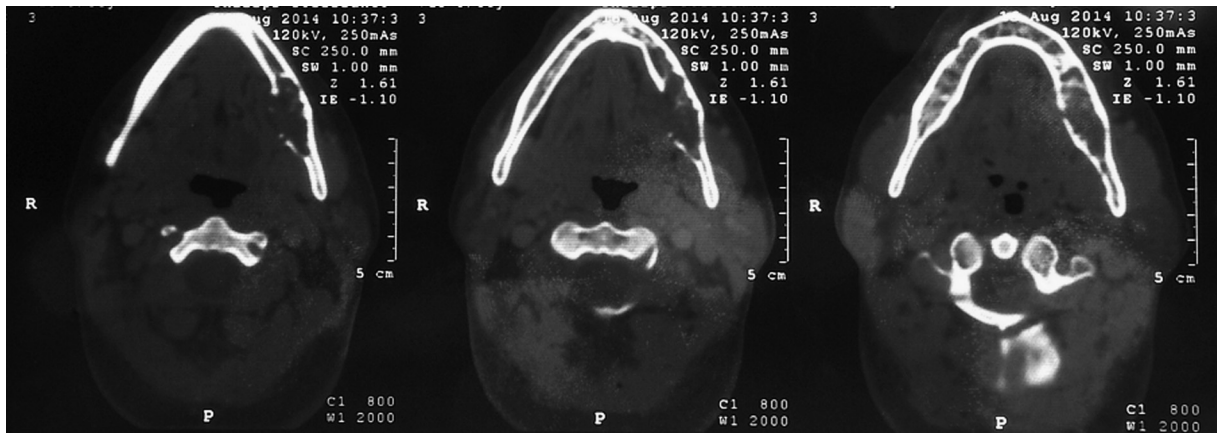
Part of the computed tomography scan showing an osteolytic lesion of the left posterior mandible, with expansion and resorption of the lingual bone plate.
